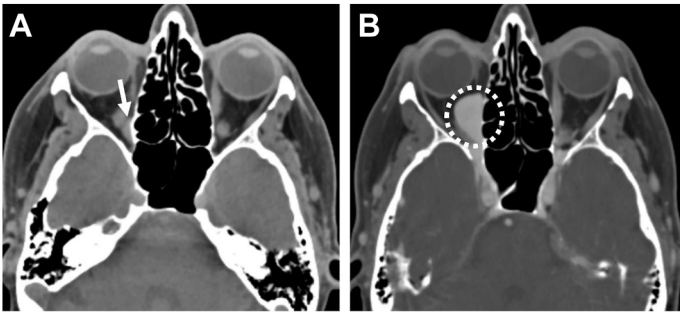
Patient with history of lymphoma with new orbital mass reported on surveillance neck CT. (A) Noncontrast orbit CT in resting status shows minimal soft tissue fullness in right orbit near the orbital apex (arrow). (B) Postcontrast orbit CT with Valsalva maneuver shows enlarged enhancing mass in right orbit which has similar density as the vessels (dashed circle). This dynamic appearance is most consistent with orbital venous varix and imaging with a provocative maneuver helps clinching the diagnosis.
